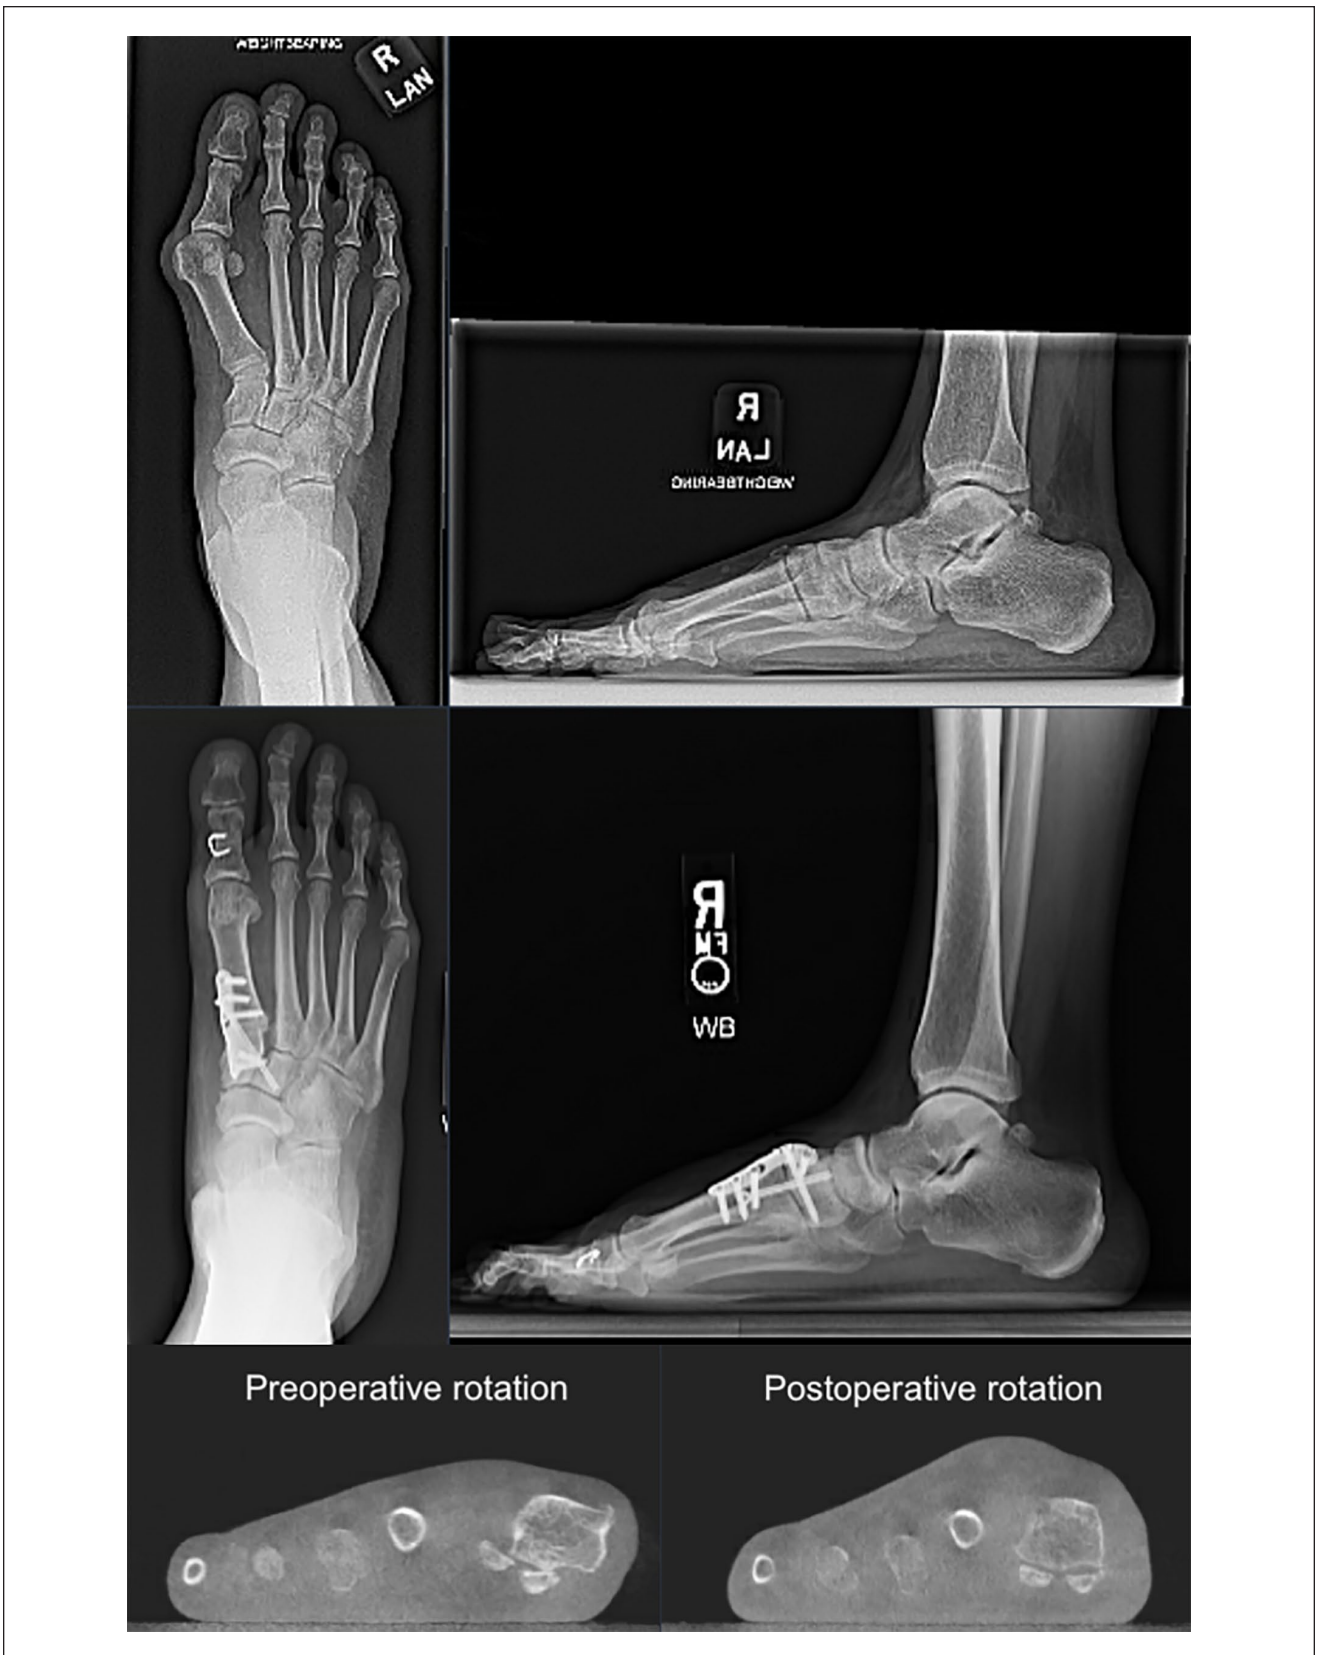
Pre- and postoperative radiographs for a case example of hallux valgus fixed with first metatarsal–second cuneiform screw and dorsomedial plate. Bottom: First metatarsal rotation evaluated on weightbearing computed tomography pre- and postoperatively.
